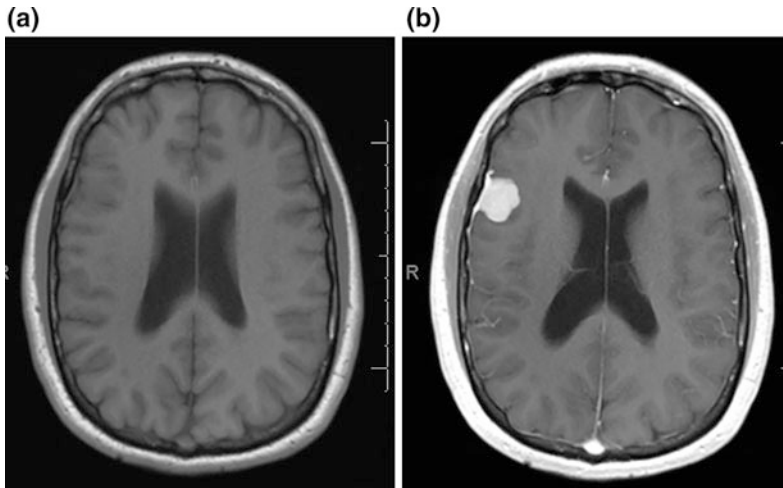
Axial pre-contrast (a) and post-contrast T1-weighted MRI (b) demonstrate an extra-axial mass overlying the right frontal operculum that is isointense to gray matter and shows homogeneous enhancement with dural tail consistent with meningioma
